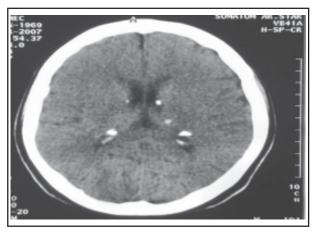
Calcified subependymal hamartomas in cranial CT scan.
